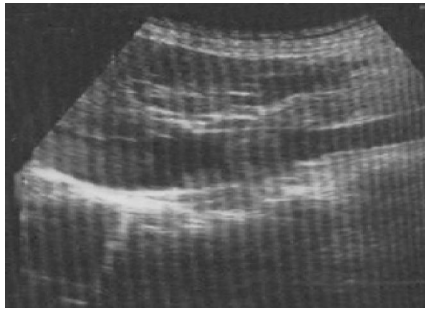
Tumor mass in the inferior vena cava (abdominal ultrasound).
